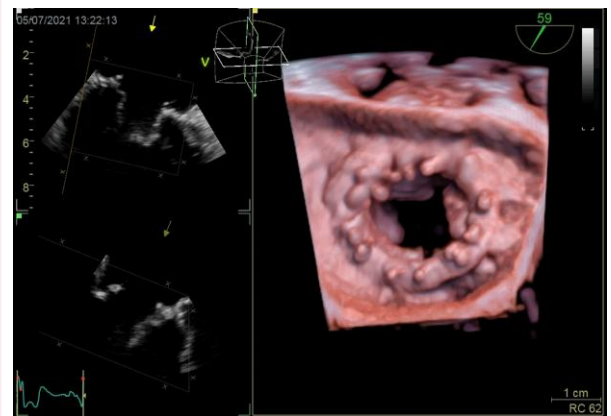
Aneurysm and dehiscence. (A) TOE at mid-oesophageal level acquired at 30°, volume rendering with transillumination. Mitral valve in a face view showing an aneurysm involving A1–2, along with two small medial vegetations (white arrows). (B) MPR of the previous study showing the profile of the aneurysm in multiple views, as well as its location between the boundary of A1–2. Also, vegetations are localized in A2 (white arrow) (Video 8). (C) Volume rendering of the same case. Longitudinal section of the mitral aneurysm. (D) MPR with colour Doppler of the same patient, displaying the integrity of this cavity in multiple planar views. (E) TOE at mid-oesophageal level acquired at 59°, volume rendering. Biological mitral prosthesis in a face view, showing suture dehiscence at the postero-medial level (white arrow) (Video 9). (F) Volume rendering of the previous case, highlighting a central regurgitant jet (small white arrow) and a larger postero-medial eccentric jet exceeding 25% of the annular circumference (large arrow). LA, left atrium; LV, left ventricle.
